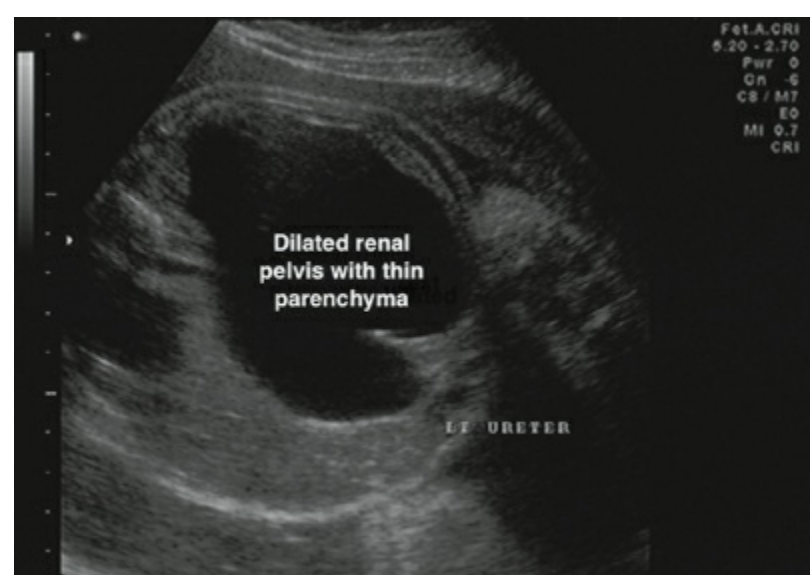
Prenatal sonography showing dilated left renal pelvis with thin parenchyma caused by ureteropelvic junction obstruction.
